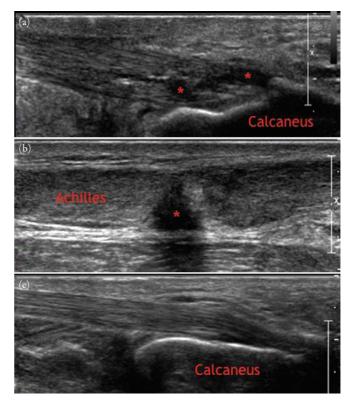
Achilles tendon tear. Panels (a) and (b), respectively, show longitudinal grayscale sonographic imaging of a patient with both insertional and noninsertional Achilles tendon tearing. Tendon tears appear as focal anechoic or hypoechoic defects (*) in the tendon. Panel (c) shows a longitudinal image of the normal contralateral Achilles tendon for comparison.
